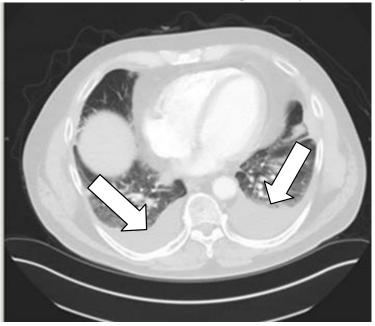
CT chest showed small to moderate right and left pleural effusion.
